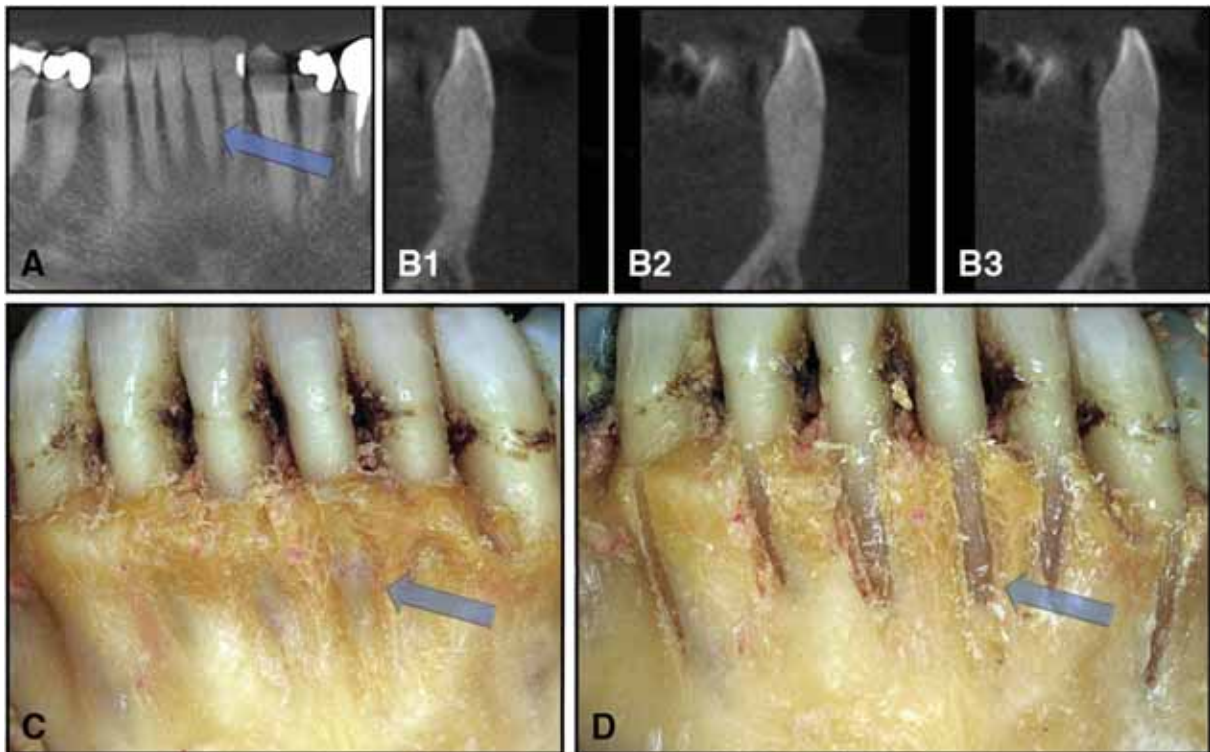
Radiological data versus clinical findings: lower left first incisor as seen on the CBCT scan: (A) Reformatted OPG view and (B) 3 slices in the sagittal view (B1 - B3). (C) Clinical view after removing the gingiva and (D) after removing the alveolar bone covering. Note that no bone covering is being depicted on the sagittal scans (B1 - B3).
